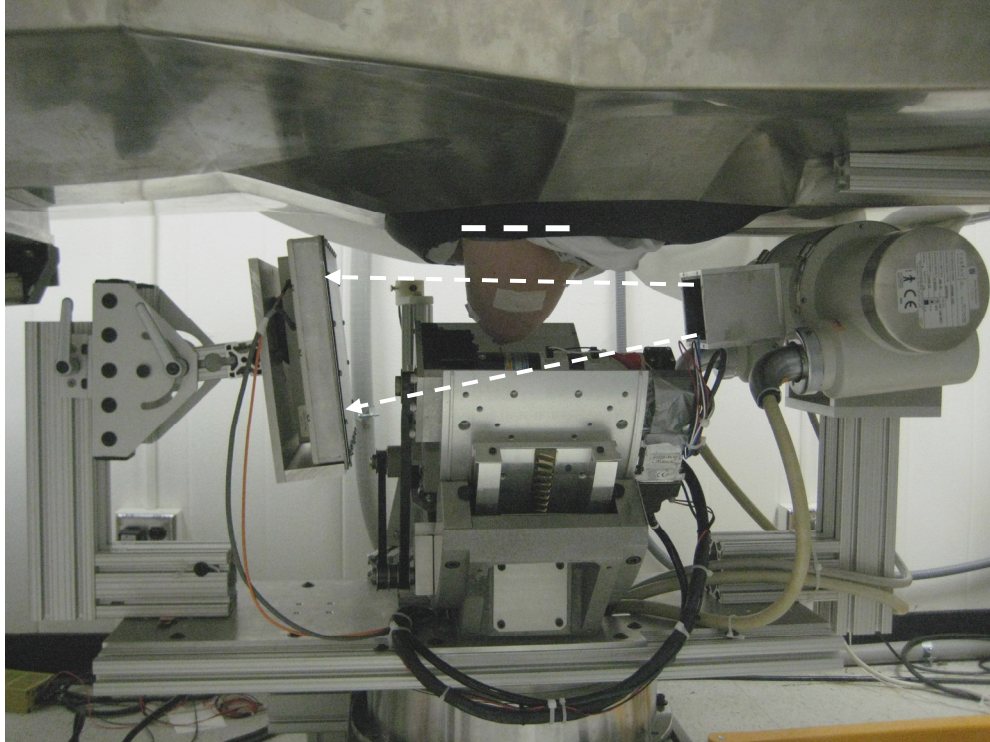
Photograph of a volunteer’s pendant breast undergoing imaging, with the bed raised to allow the system to traverse under the head section at right. The top plane of the cone beam (whose limits are approximated by the dashed arrows) is separated an estimated 4cm from the presumed chest wall (approximated by the dashed white line).
